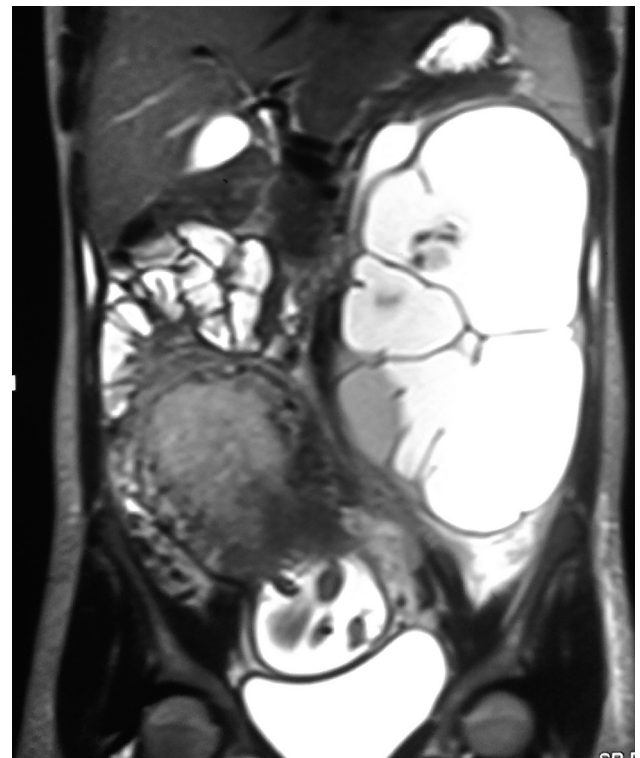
MRI Showing urinary bladder, foetal head, lower portion of hydronephrotic left kidney occupying lower abdomen and pelvis.
